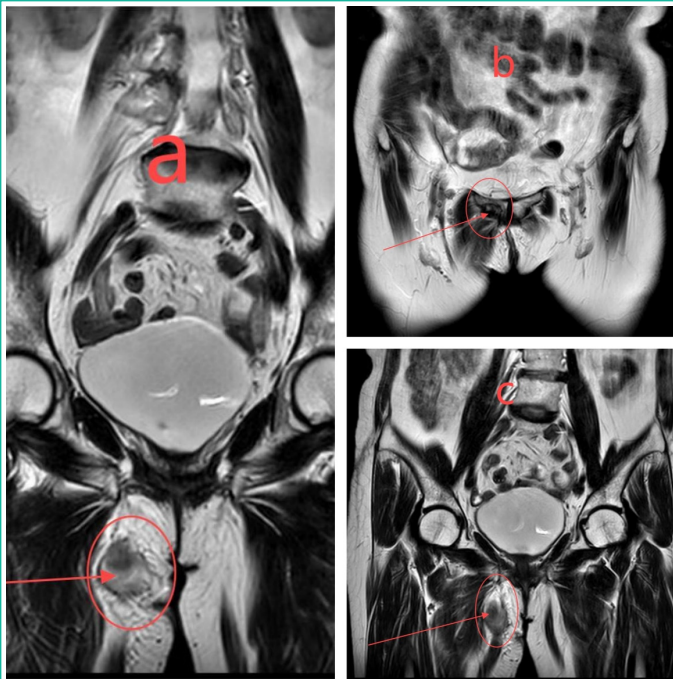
a-c) MRI showed: right thin femoral muscle peripheral mass shadow and oozing, right pubic bone abnormal signal, combined with the history of the possibility of tuberculosis infection.
